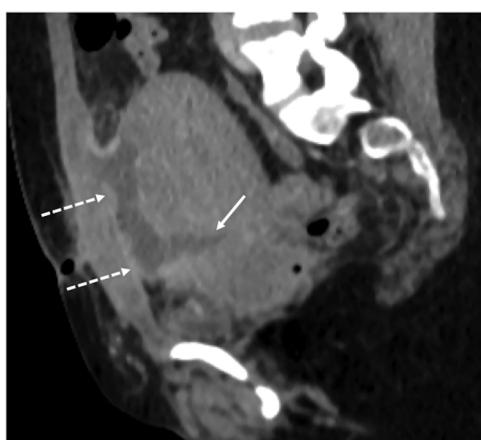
Uterine dehiscence in a 35-year-old woman on the fourth day following a Caesarian birth with persistent fever and pelvic pain. CT images revealed a preuterine collection (dotted arrows) continuous with solution of continuity with the anterior aspect of the uterus, in the area of the Caesarian scar (arrow).
